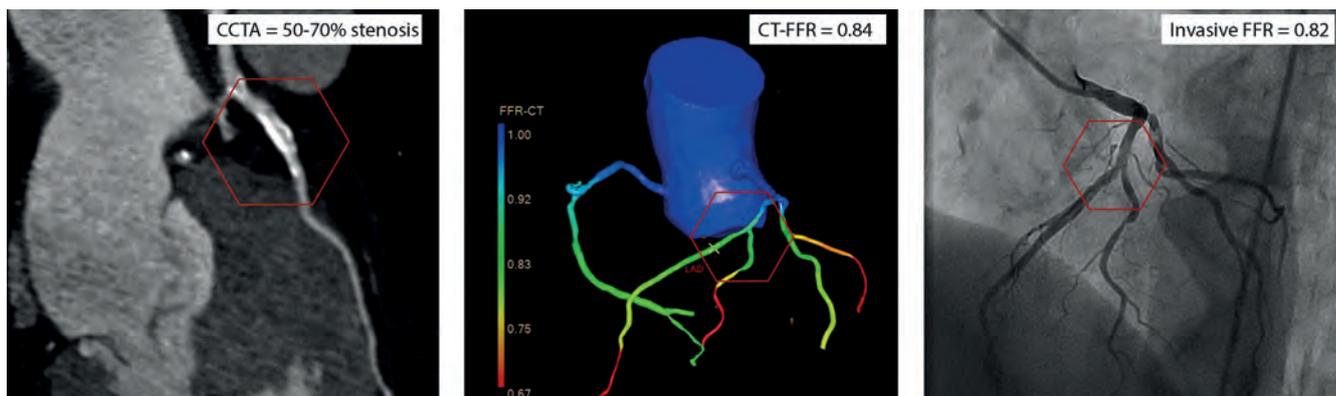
Examples of CCTA, CT-FFR and invasive FFR in a study patient. An Agatston CCS of 707 is observed. CCTA shows a significant stenosis of the mid LAD, whereas the CT-FFR indicates non-significant ischemia. SPECT perfusion imaging indicates mild to moderate ischemia proximal anterolateral and proximal inferoposterolateral. Invasive FFR measurements demonstrates obstructive stenosis and a FFR value of 0.82 indicating no vessel ischemia.
